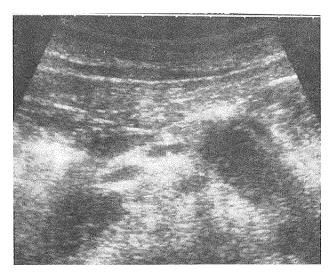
Duct-penetrating sign by abdominal ultrasonography in AIP (tumor-forming type). The main duct is found to penetrate through the mass (duct-penetrating sign) in the case of a locally enlarged pancreas, which may be a useful sign for the differential diagnosis against pancreatic cancer
